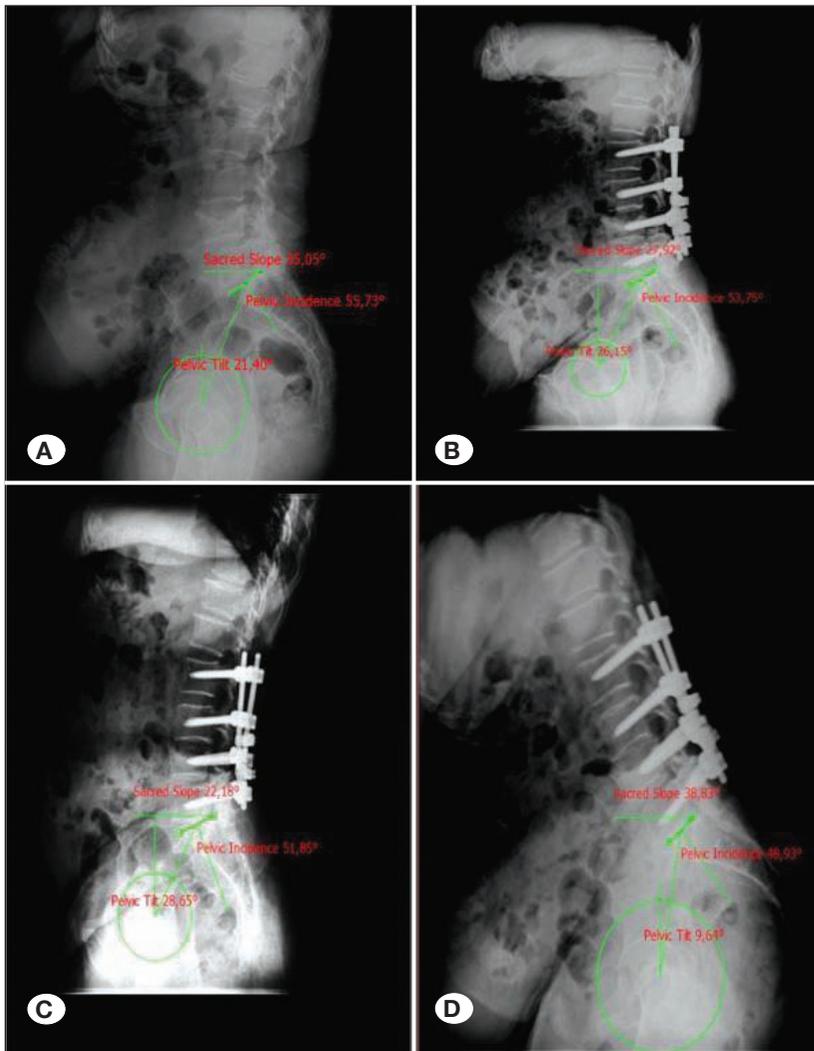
A) Lateral radiograph of a preoperative patient with lumbar spinal pathology. B-D) Postoperative radiological sagittal balance assessments after posterior segmental stabilization between L2 and S1 levels.
